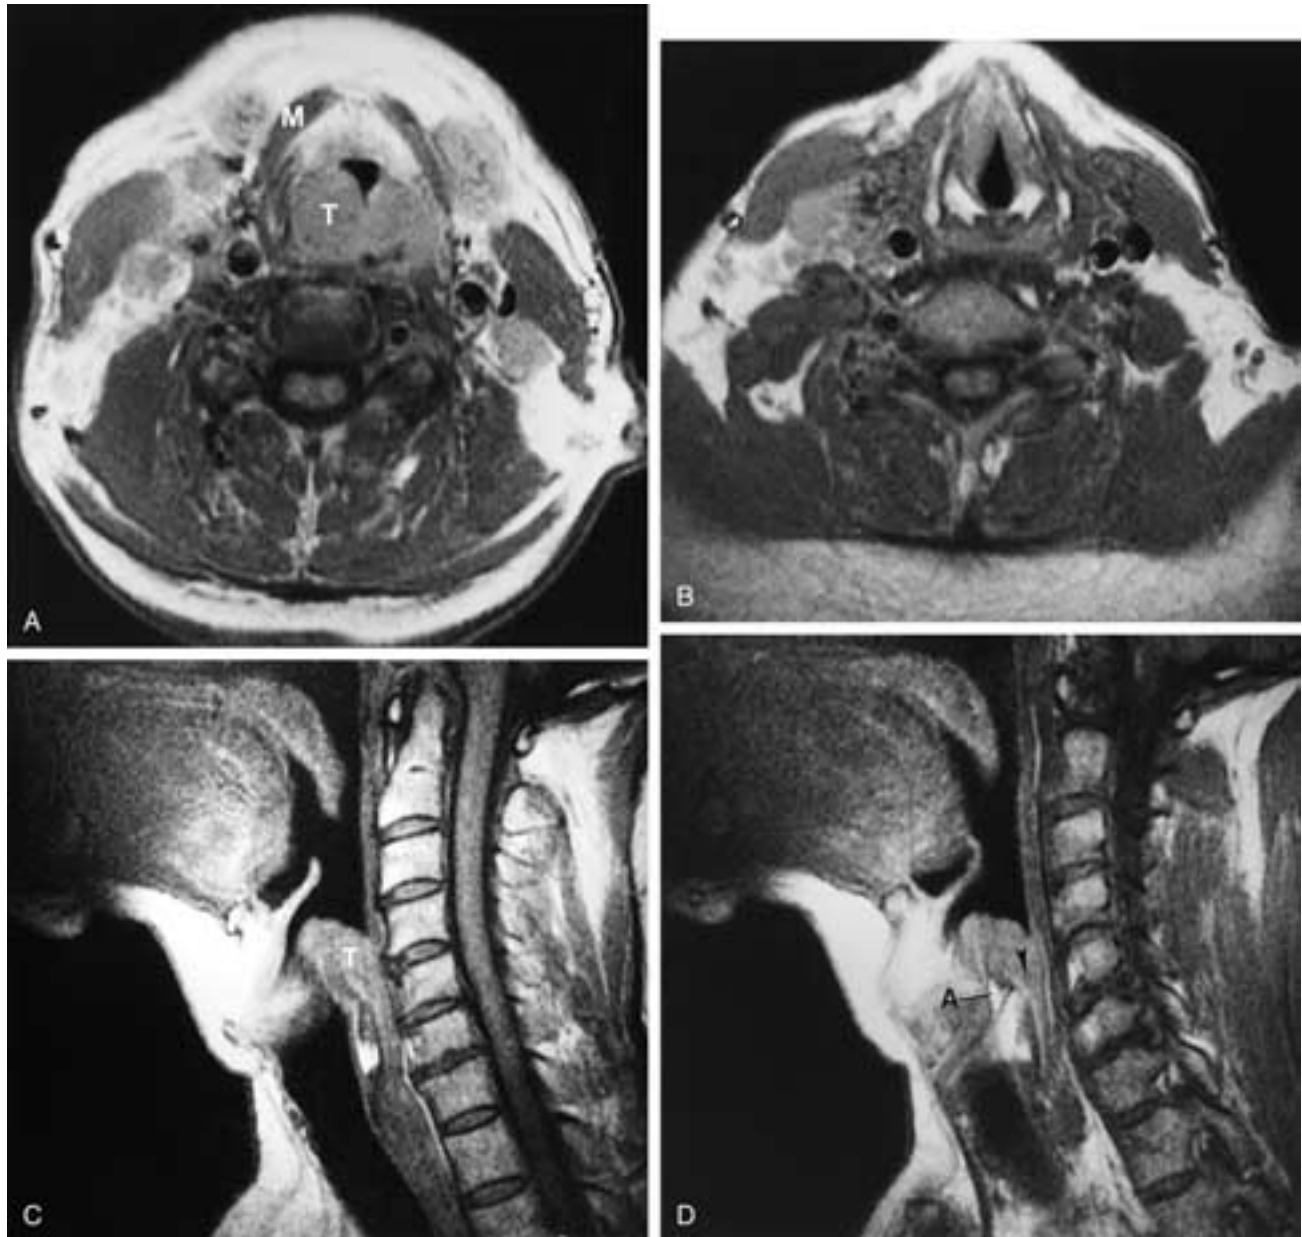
Interarytenoid tumor, .35 Tesla. A, Scan through the supraglottic larynx shows the tumor (*T*). *M*, Strap muscle. B, Level of the cricoid; tumor is no longer seen. C, Sagittal (near midline) T1-weighted image shows the tumor (*T*) just superior to the cricoid. D, Slightly lateral scan shows the tumor extending behind (arrowhead) the arytenoid (*A*). The lower margin of the tumor is at the level of the upper margin of the cricoid lamina. (Courtesy of Dr. Robert Lufkin.)
